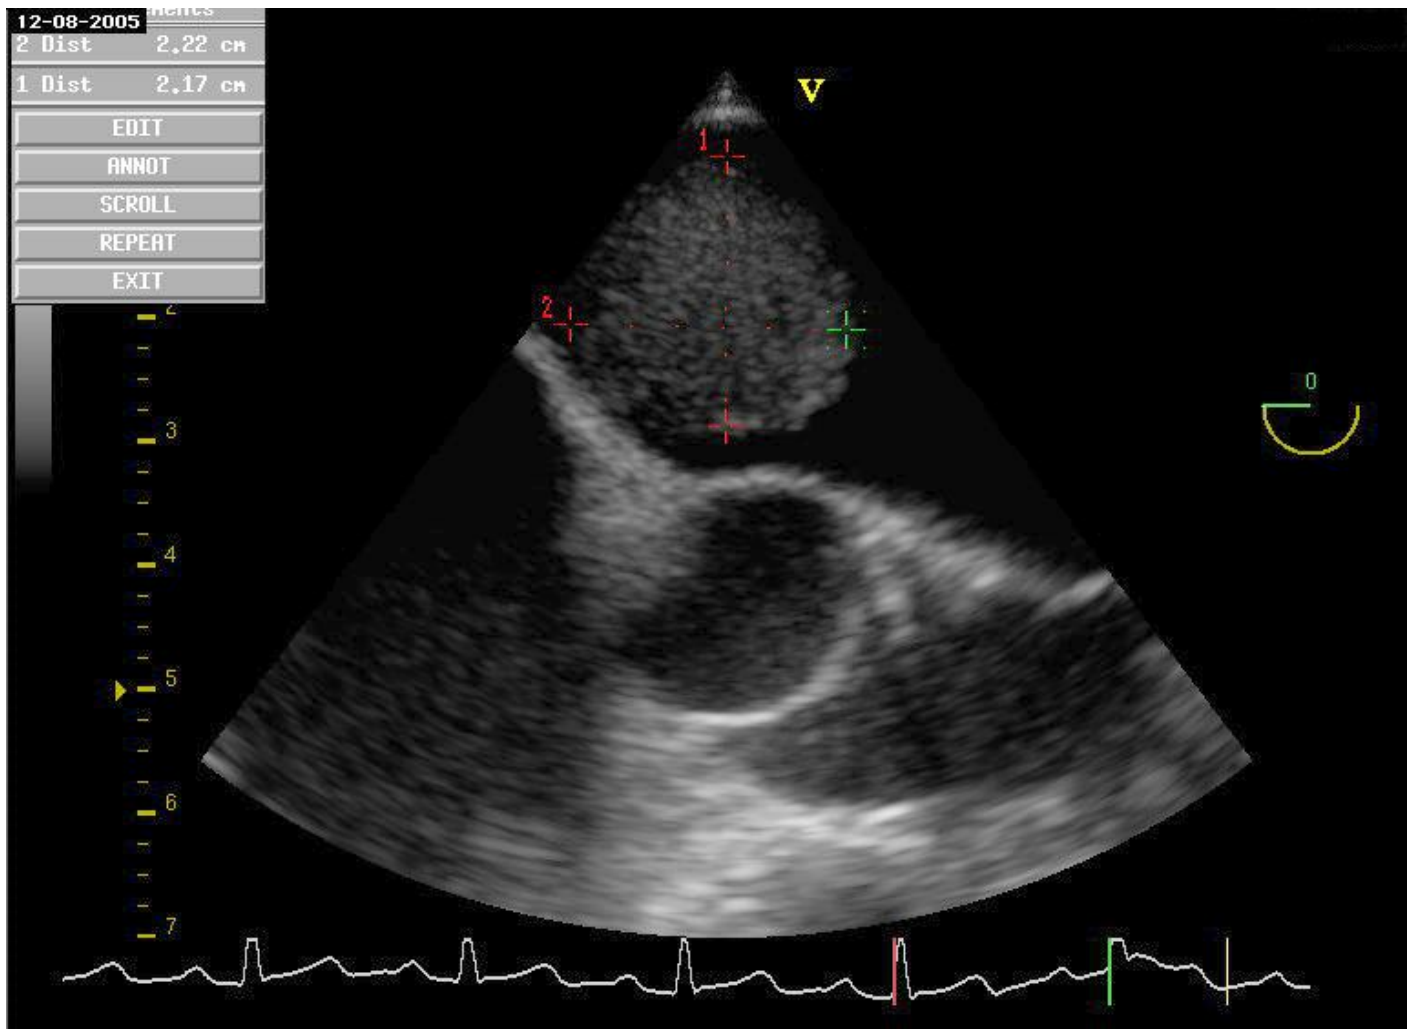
Picture of echocardiogram
